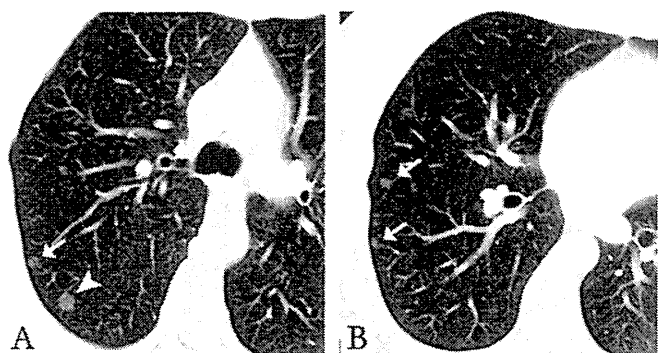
CT of multicentric GGNs of AIS/AAH. *A* and *B*, Multiple subsolid nodules (arrows) on axial 3-mm CT images show differing sizes and attenuation. These were presumed to represent preinvasive lesions (AAH and AIS). Because the dominant nodule in the right upper lobe posteriorly near the fissure in part *A* (large arrowhead) appears somewhat dense, it was excised surgically and found to be nonmucinous AIS. AAH, atypical adenomatous hyperplasia; AIS, adenocarcinoma in situ; CT, computed tomography; GGN, ground-glass nodule.
